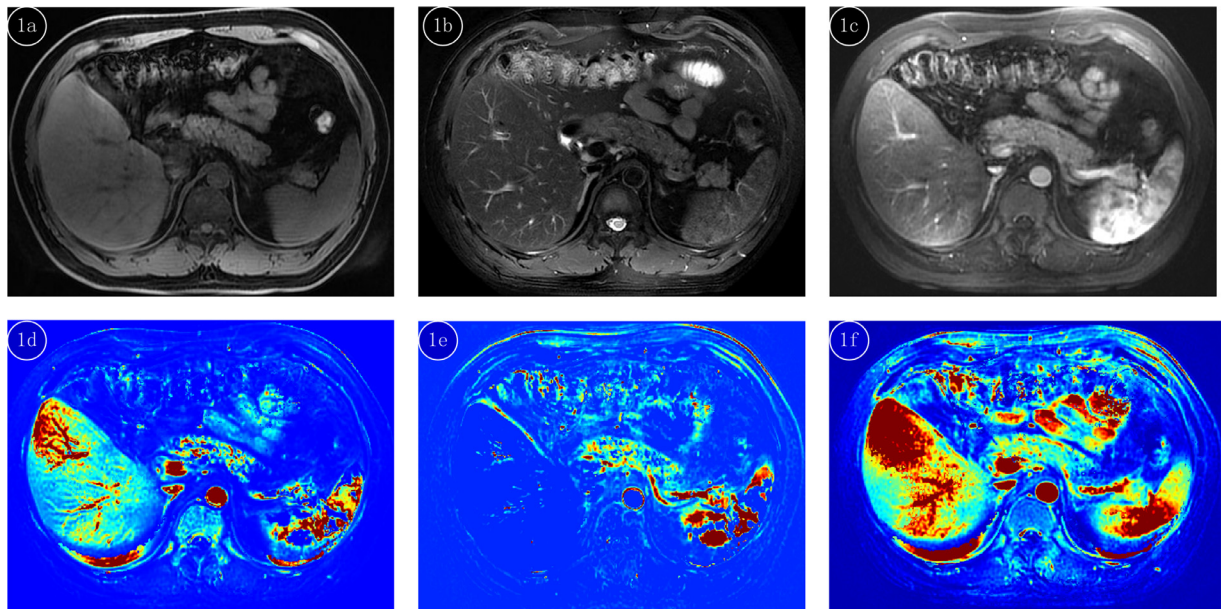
A 42-year-old male with a normal pancreas. (a) T1 WI; (b) Fat suppression T2 WI; (c) MRI-enhanced map; (d) K^{trans} map; (e) V_p map; and (f) AUC map. AP, acute pancreatitis; AUC, area under the concentration curve; MRI, magnetic resonance imaging.
